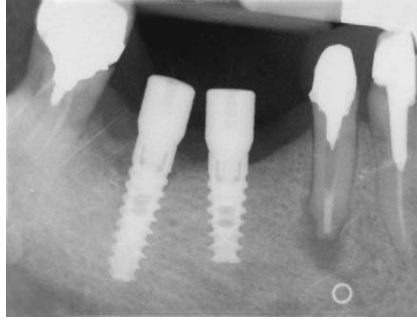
Six-month postoperative radiograph showing complete healing. (Courtesy of Pablo Schilman, DDS, Ramat Hasharon, Israel.)
